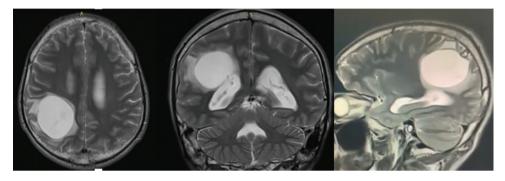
T2 sequence brain MRI visualizing a well-limited cerebral cystic mass.
